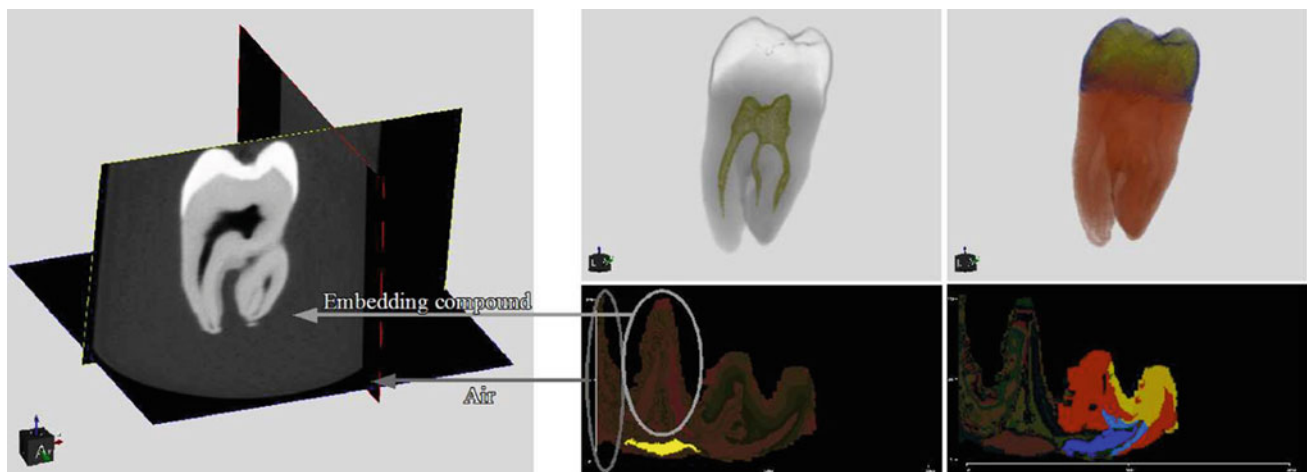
SSE histograms and 3D visualization for CT data of a tooth. On the *left*, the original image data is shown using a plane-based visualization. It can be seen that the tooth is embedded in some compound which is surrounded by air. The latter structures mainly occupy the left part of the SSE histogram. A clustering of the 2D bins by spatial classification and a highlighting of the nerve cavity is shown in the *middle* column.
